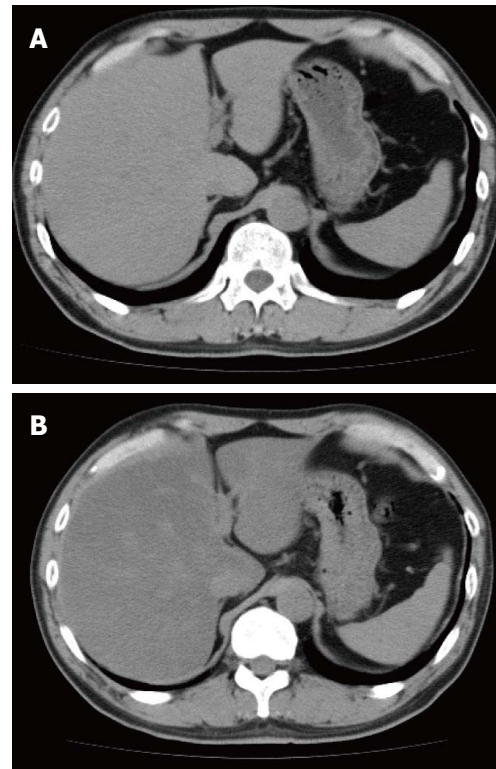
Abdominal computed tomography scans of a pancreatic cancer patient before (A) and during treatment (B) with S-1, showing that the liver/spleen ratio decreased after start of treatment.
